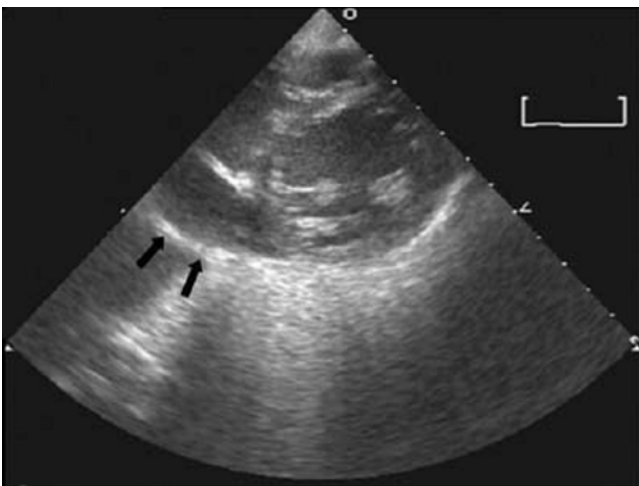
On the parasternal short-axis view, echocardiography showed a large amount of anterior pericardial effusion (arrows) without diastolic right ventricular compression.
